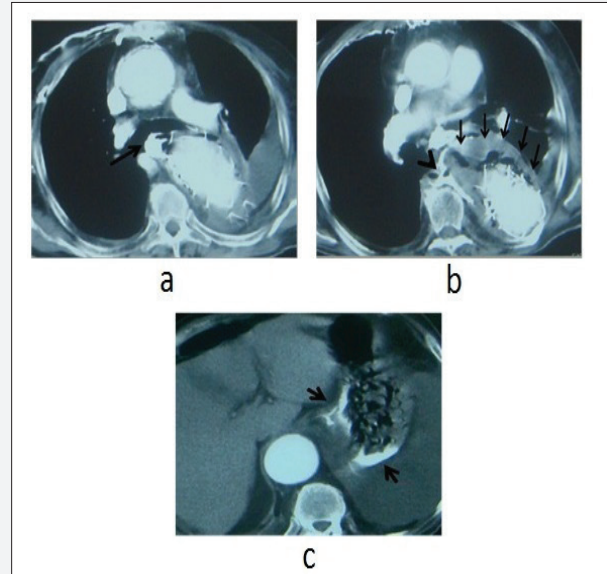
CT images taken on the arterial phase after giving only intravenous contrast agent; a) Contrast agent nearly filling the whole esophagus location at the level of trachea bifurcation (black arrow). b) Collection of air and fluid (sequential black arrows) in the periaortic area together with the extravasated aortic contrast agent (black arrow head). c) Gastric mucosa coated with the contrast agent (small black arrows).
